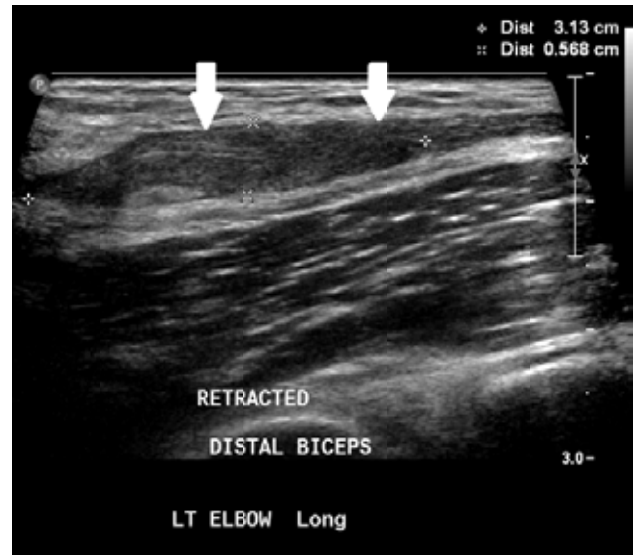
Ultrasound showing biceps tendon retraction causing bunching and thickening of the torn tendon stump.
